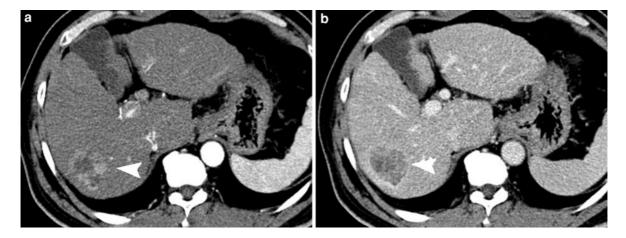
Advanced HCC: typical appearance. a Arterial phase CT scan shows a heterogeneously enhancing nodule in segment 7 (*arrowhead*). b Delayed phase CT scan shows washout and a hyperattenuating capsule
